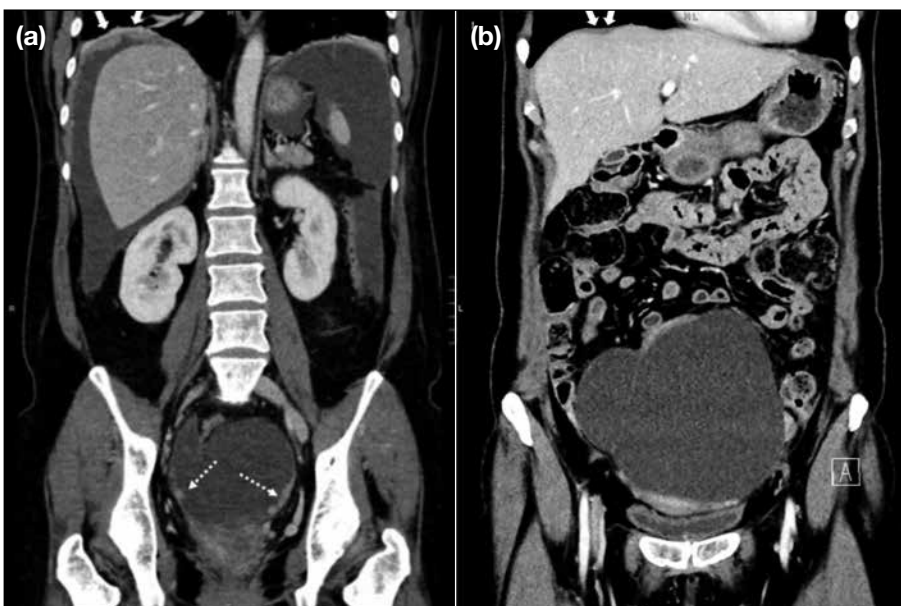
(a) Staging computed tomography (CT) image showing extensive peritoneal deposits at the right subphrenic region (arrows), which are surgically challenging. The primary ovarian tumour with solid components (dashed arrows) is also detected. (b) Follow-up CT after neoadjuvant chemotherapy showing interval shrinkage of the concerned right subphrenic deposits (arrows). The primary tumour also shows a decreased solid component. Images were reviewed at the multidisciplinary meeting and the patient subsequently underwent interval debulking surgery.
